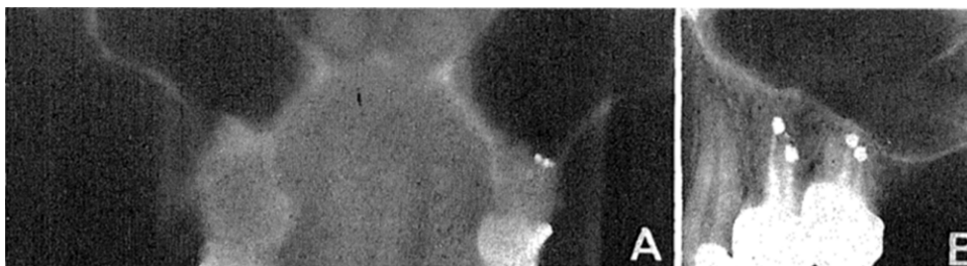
A case of oroantral communication. Fifteen months postoperatively the tomogram shows no bony partition between apex of tooth and maxillary sinus (A), while apical radiograph was interpreted as complete bone regeneration (B).
